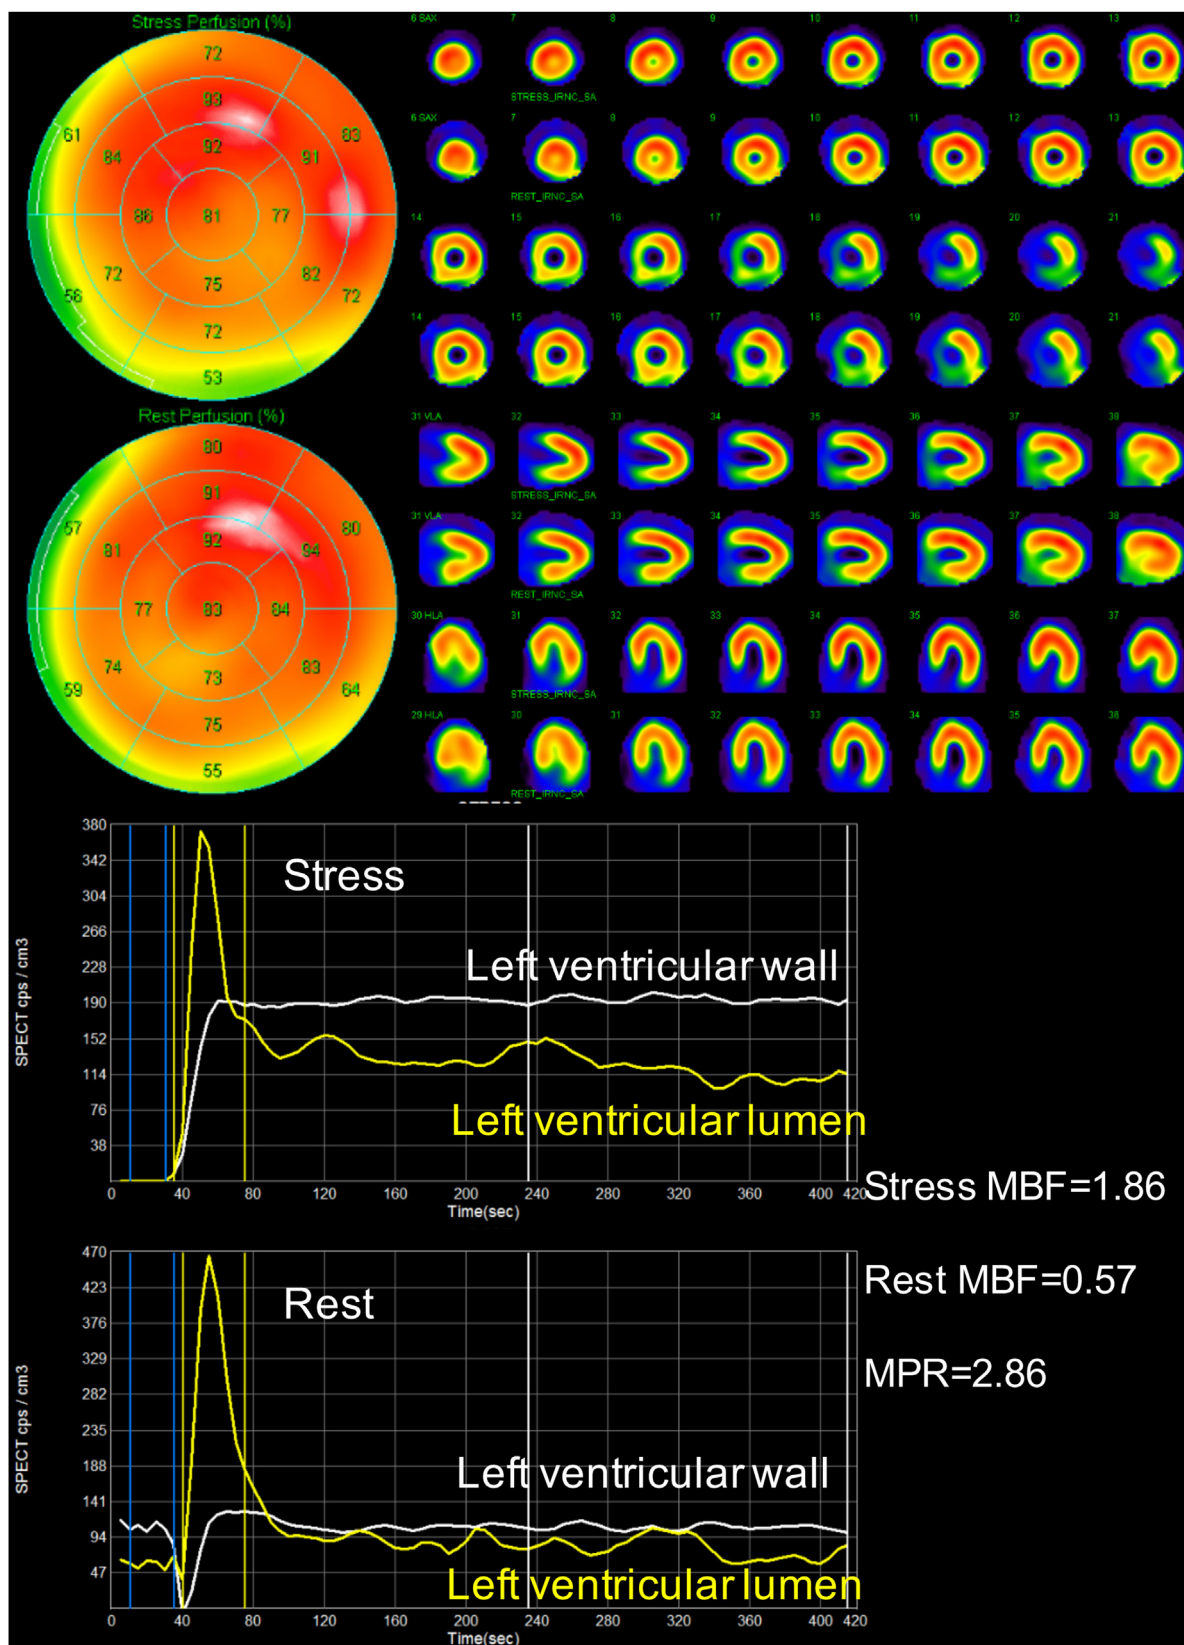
Representative cases. Upper panels are myocardial perfusion SPECT (MPS) images. Lower panels are time activity curves for quantitative MPS. Yellow lines show the left ventricular blood pool curves as input functions and white lines show the left ventricular myocardium curves as output functions. (A) 74-year-old man without significant stenosis on coronary angiography. (B) Image obtained from a 48-year-old man with 3-vessel stenosis on coronary angiography (left anterior descending artery segment 7, 75%; left circumflex artery segment 11, 75%; segment 13, 75%; right coronary artery segment 3, 75%), chronic kidney disease and diabetes mellitus. Both A and B show a normal range of the summed stress score. However, myocardial perfusion reserve (MPR) and myocardial blood flow (MBF) in case B show low value of 1.72 and 0.91 against 2.86 and 1.86 in case A, respectively.
